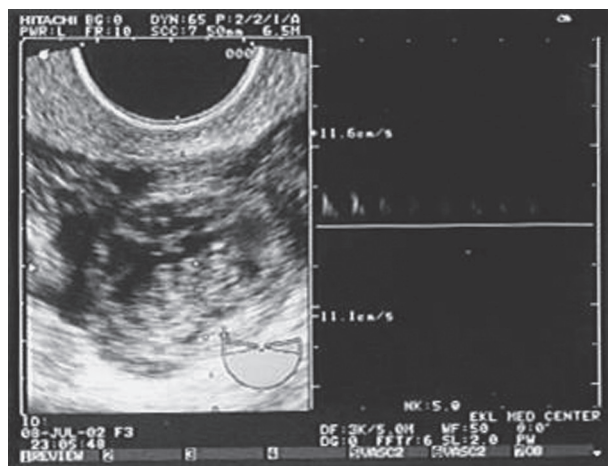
Fetal heart movements detected by ultrasonography in the fallopian tube, diagnostic of an ectopic pregnancy. (Courtesy Dr. Mary Ann Edens.)
